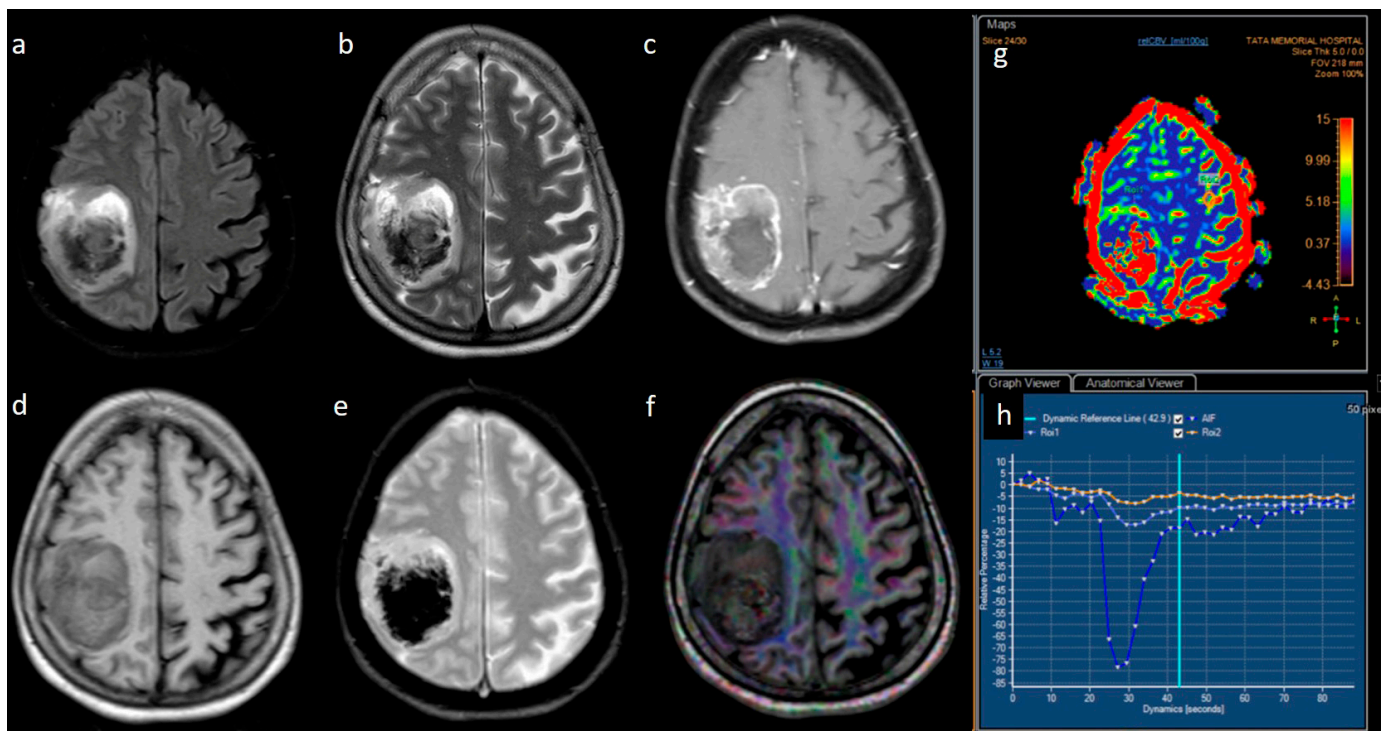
(a–h) FLAIR, T2, T1, post-contrast T1, GRE, DTI, perfusion color map, and graph representing an IDH-wildtype glioblastoma. Images a–e reveal a heterogeneous peripheral rim-enhancing right frontoparietal mass with significant internal necrosis and hemorrhage. Image f is a DTI image that shows subcortical and adjacent parenchymal infiltration. Images g and h reveal significant hyperperfusion.
